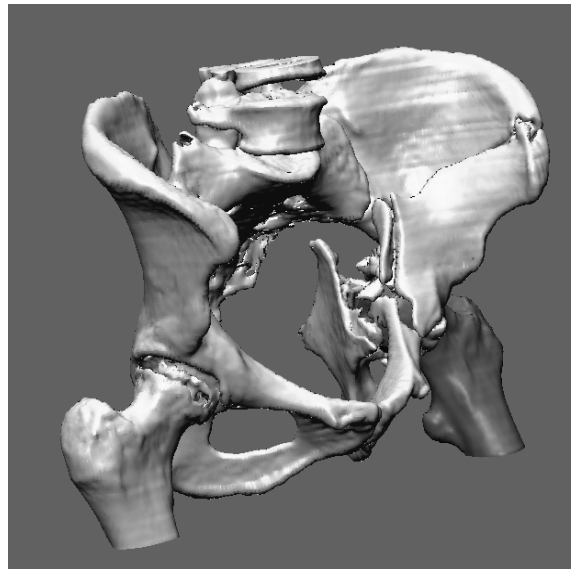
3D image of a pelvis with multiple fractures from CT in a semi-frontal view.
